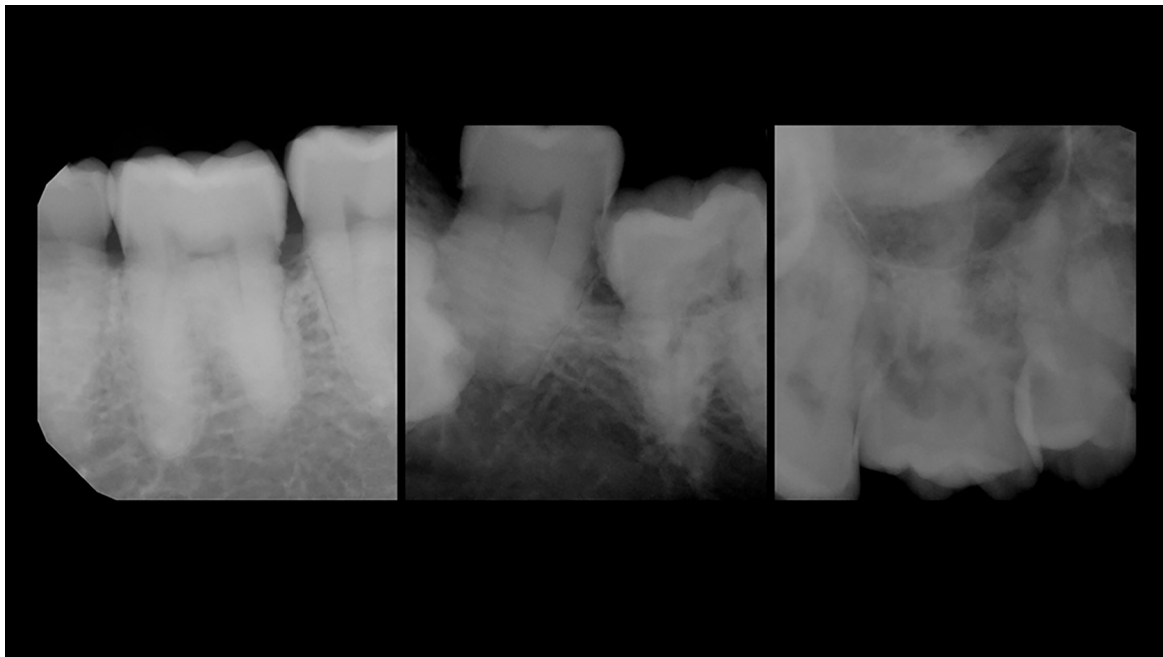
Peri-apical radiographs taken on November 1, 2021 showing hypercementosis and infraocclusion.
